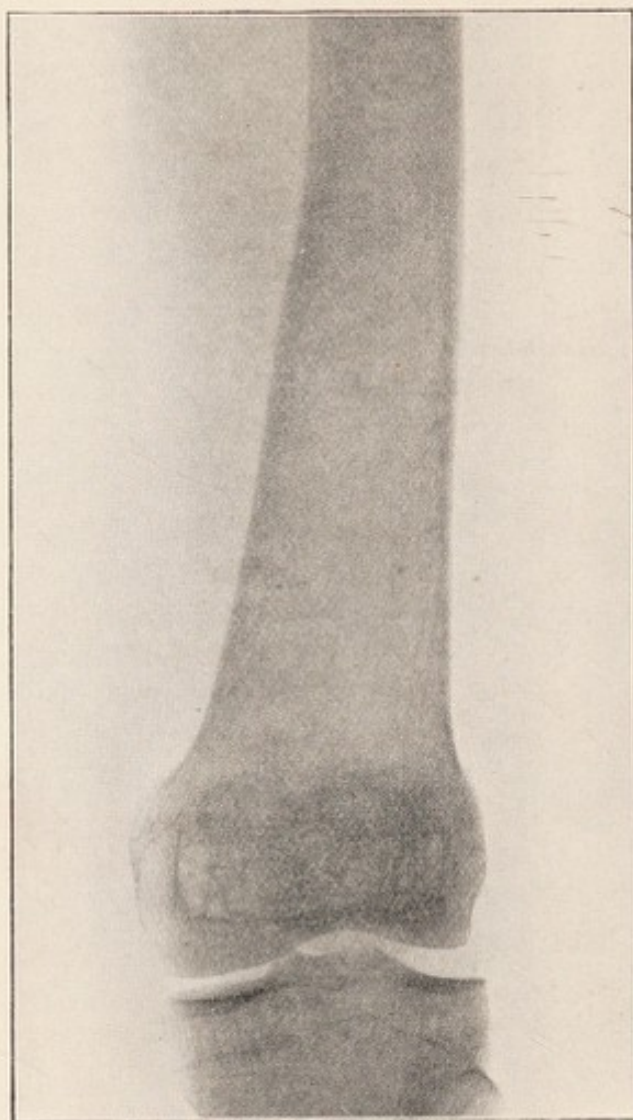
X-ray of same case, eighteen years after operation (1927).
